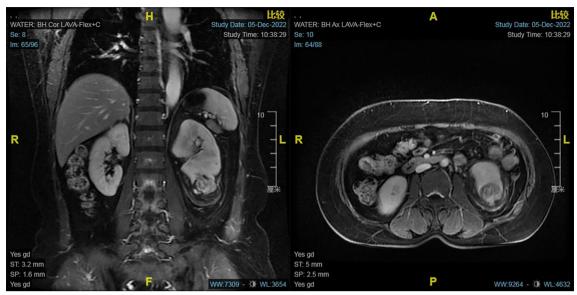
Magnetic resonance imaging (MRI) findings of the epithelioid angiomyolipoma
